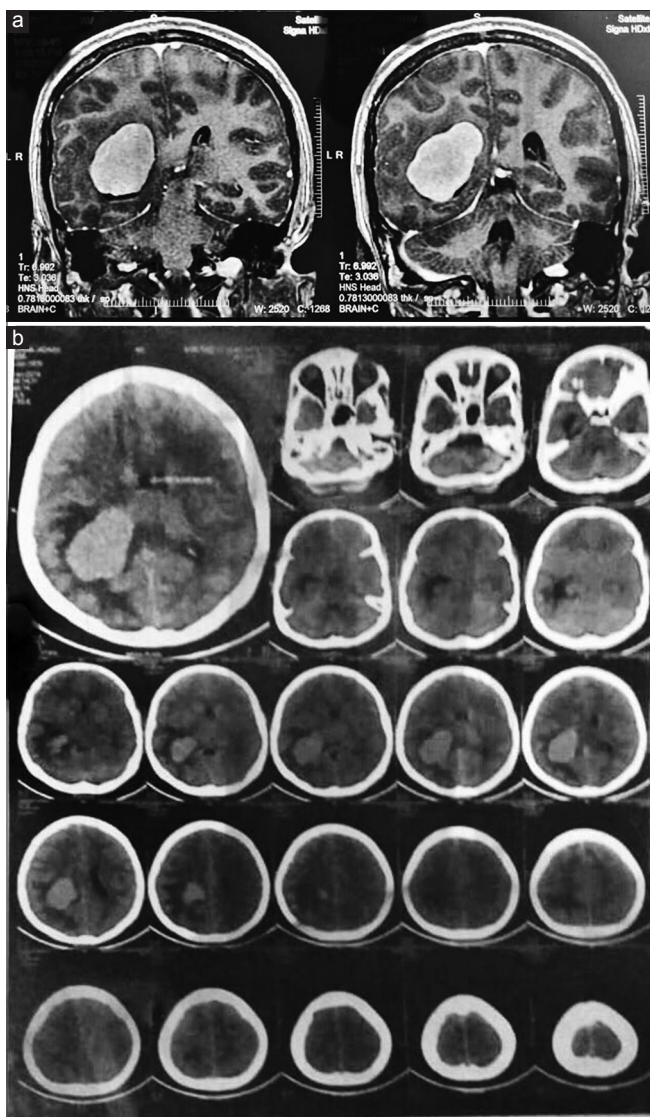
(a and b) Magnetic resonance imaging reveals an intensely enhancing lobulated mass expanding the atrium and the occipital horn of the lateral ventricle with mild perilesional vasogenic edema
